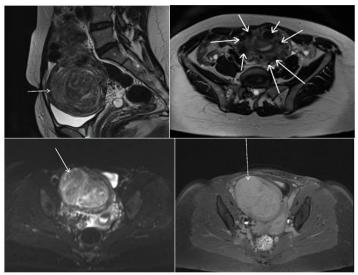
Pelvic MRI in T2 sagittal (A), T2 axial (B), Axial Diffusion (C) and Axial T1 Fatsat Gado (D) slices showing a polymyomatous uterus (arrows) with the largest (A, C, D) right anterior isthmic subserous in discrete diffusion hypersignal, without clear restriction of ADC in favour of a cellular and hyper vascularized myoma.
